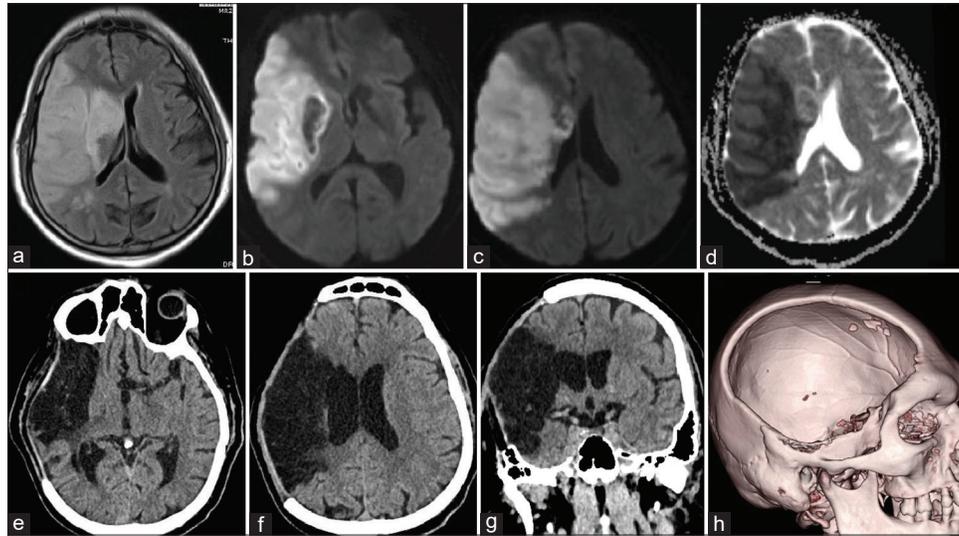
Axial FLAIR (a) and Diffusion-weighted (b and c) with ADC MR images (d) of a patient with a large right MCA territory infarct. Postoperative axial (e and f) CT images show no residual midline shift and with mass effect and extent of bone removal in AP dimensions while the coronal (g) reconstruction shows decompression in the superoinferior axis. A 3D reconstruction of the large DC that was achieved by the linear posteriorly directed incision (h) is also shown. FLAIR: Fluid attenuated inversion recovery, ADC MR: Apparent diffusion coefficient magnetic resonance, MCA: Middle cerebral artery, CT: Computed tomography, AP: Anteroposterior, DC: Decompressive craniectomy
